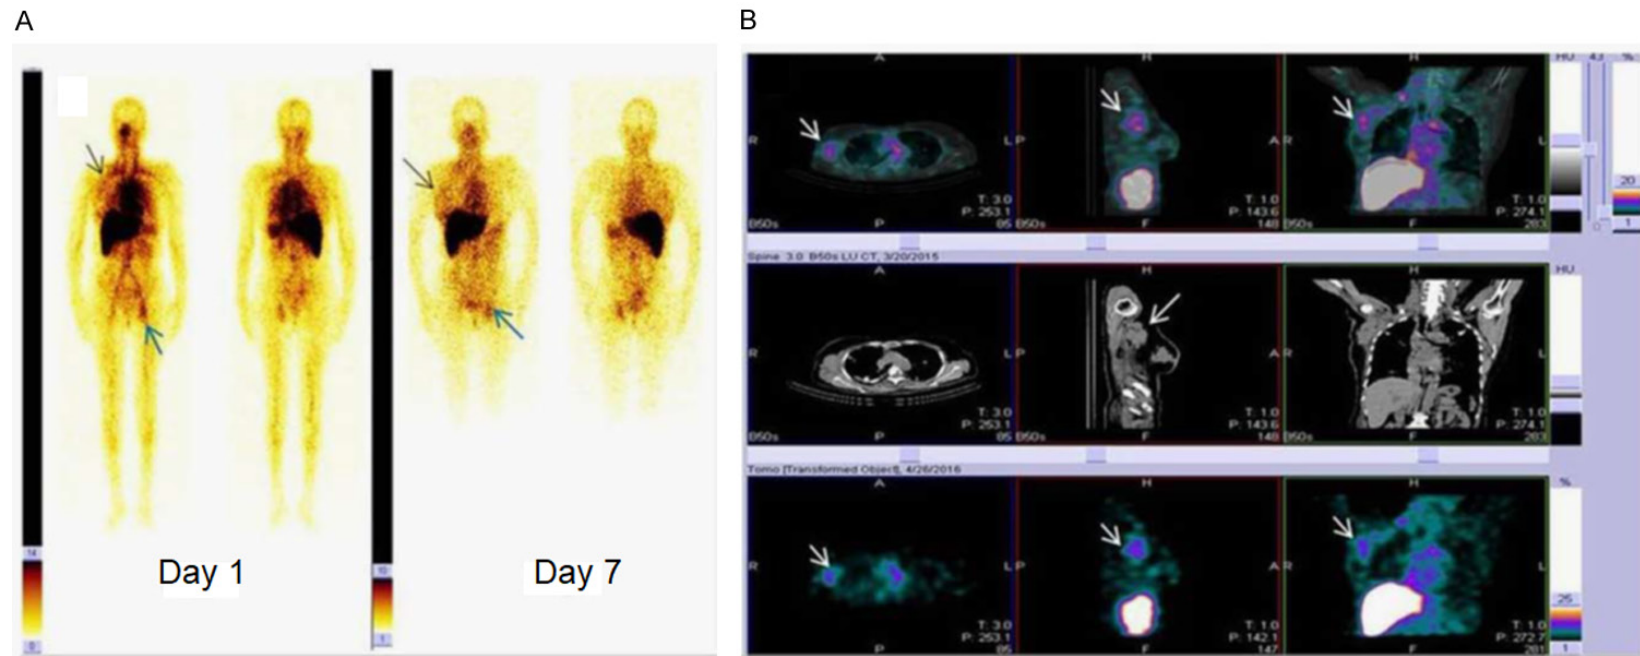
A 60-year-old breast cancer patient (HER2 +ve) was administered with ^{177}Lu -DOTA-trastuzumab therapy. A. WBS at day 1 and day 7 post administration of ^{177}Lu -DOTA-trastuzumab. Tracer uptake can be observed in primary breast tumor (black arrow head). The bone metastasis in the acetabulum region was visualized at day 1 and day 7 (blue arrow heads). B. SPECT/CT, CT, and SPECT images showing lymph node metastases which could not be localized on WBS (white arrow heads). Adapted from Ref [171].
